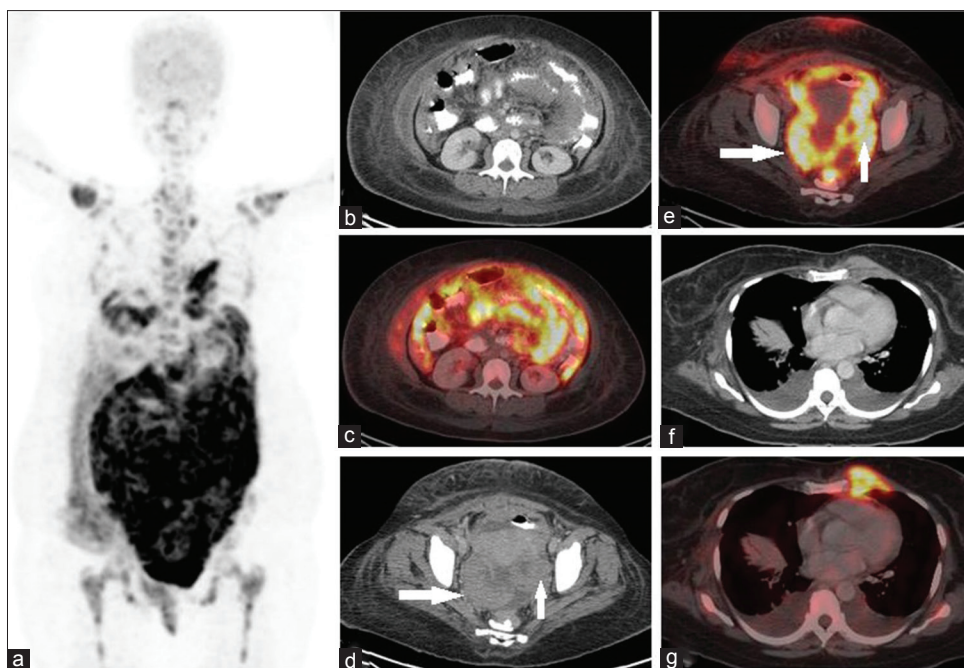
Whole-body F-18 fluorodeoxyglucose positron emission tomography-computed tomography (a, maximum intensity projection image), shows intensely fluorodeoxyglucose-avid diffuse soft-tissue thickening in the peritoneum, omentum, mesentery, along the serosal surface of small and large bowel loops (b and c) and fluorodeoxyglucose-avid lesions in both adnexae (d and e, white arrows). In addition, fluorodeoxyglucose-avid soft-tissue lesions were also seen in the left parasternal region along with metabolically inactive bilateral pleural effusion (f and g)
